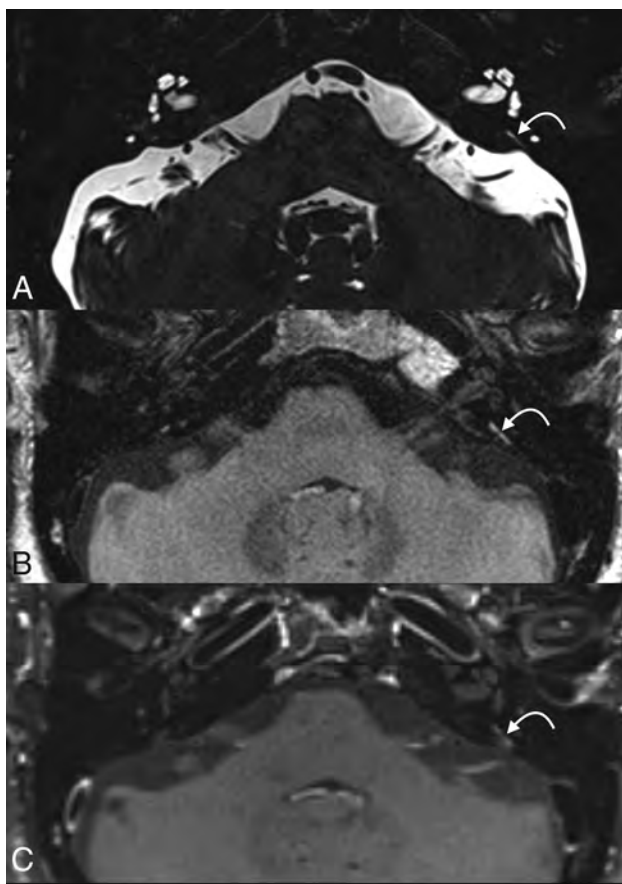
An example of VA enhancement. The VA is visible on thin-section 3D SPACE FSE T2 image (A), which demonstrates a normal-caliber aqueduct. Prominent enhancement is seen on postgad FLAIR image (B), while less prominent enhancement is seen on postgad T1-FS image (C). The curved arrow points to the vestibular aqueduct.
